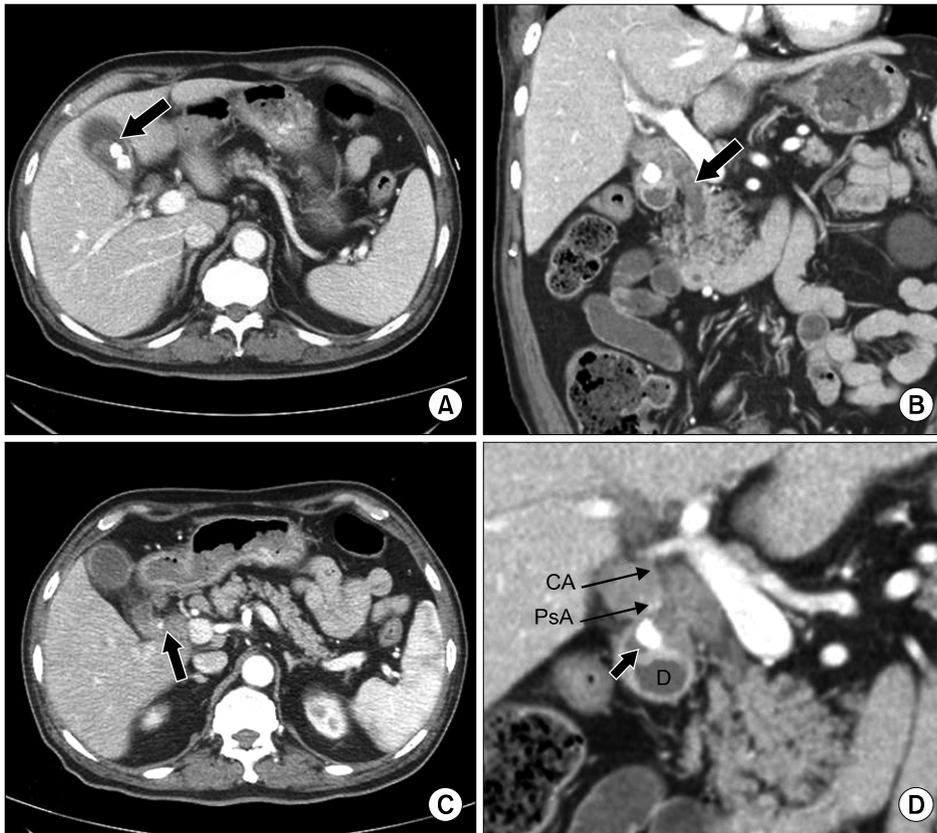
Abdominal computed tomography (CT) findings. Contrast-enhanced CT images show acute calculous cholecystitis with intragallbladder (GB) hemorrhage (arrow) (A), high density material (arrow) filling the common bile duct (hemobilia) (B), a small-sized pseudoaneurysm of the cystic artery (arrow) (C), and a fistulous tract between the GB and the duodenum (cholecystoduodenal fistula) with a stone (arrow) adjacent to the second portion of the duodenum (D). CA, cystic artery; PsA, pseudoaneurysm; D, duodenum.
